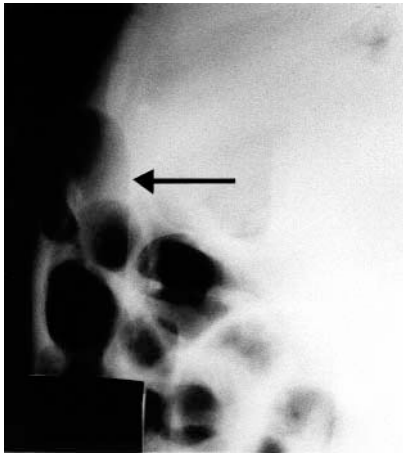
Lateral chest radiograph showed bowel loops within the presternal soft tissue at lower edge of the thorax.
